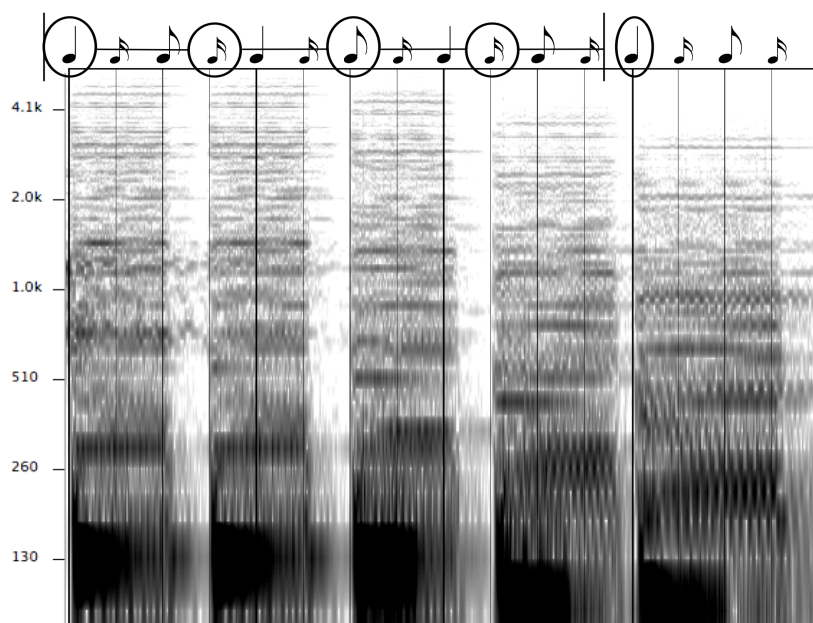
Excerpt from sonogram of 808 State’s *Cübik (Kings County Perspective)*, 0:01–0:03, placed in a grid with note values. Entry points are highlighted with circled notes.
